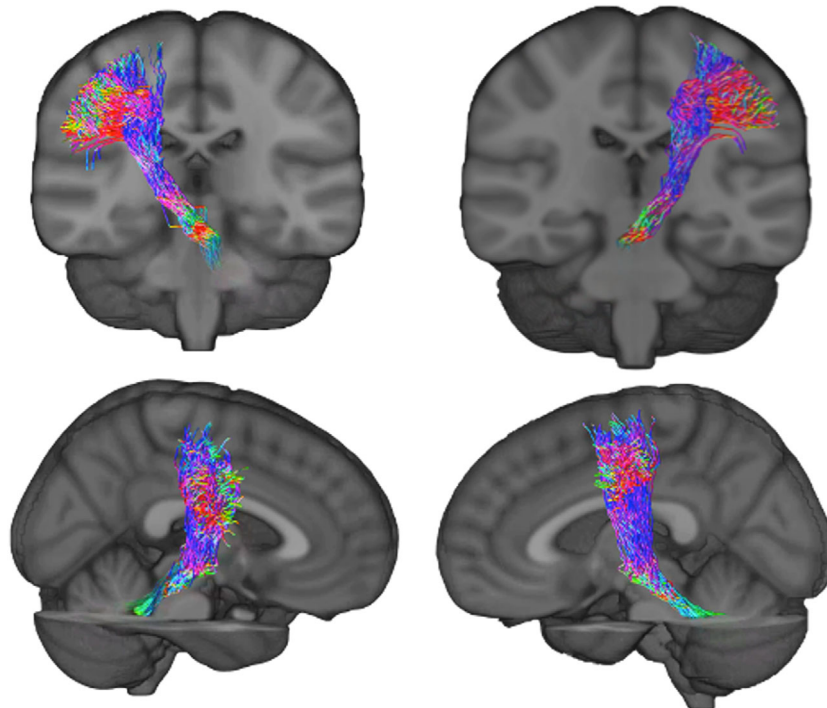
Coronal (upper row) and sagittal (lower row) planes showing an example of the left and right DTT obtained at the end of the dMRI processing steps. DTT, dentate-thalamo-cortical tract; dMRI, diffusion MRI.
